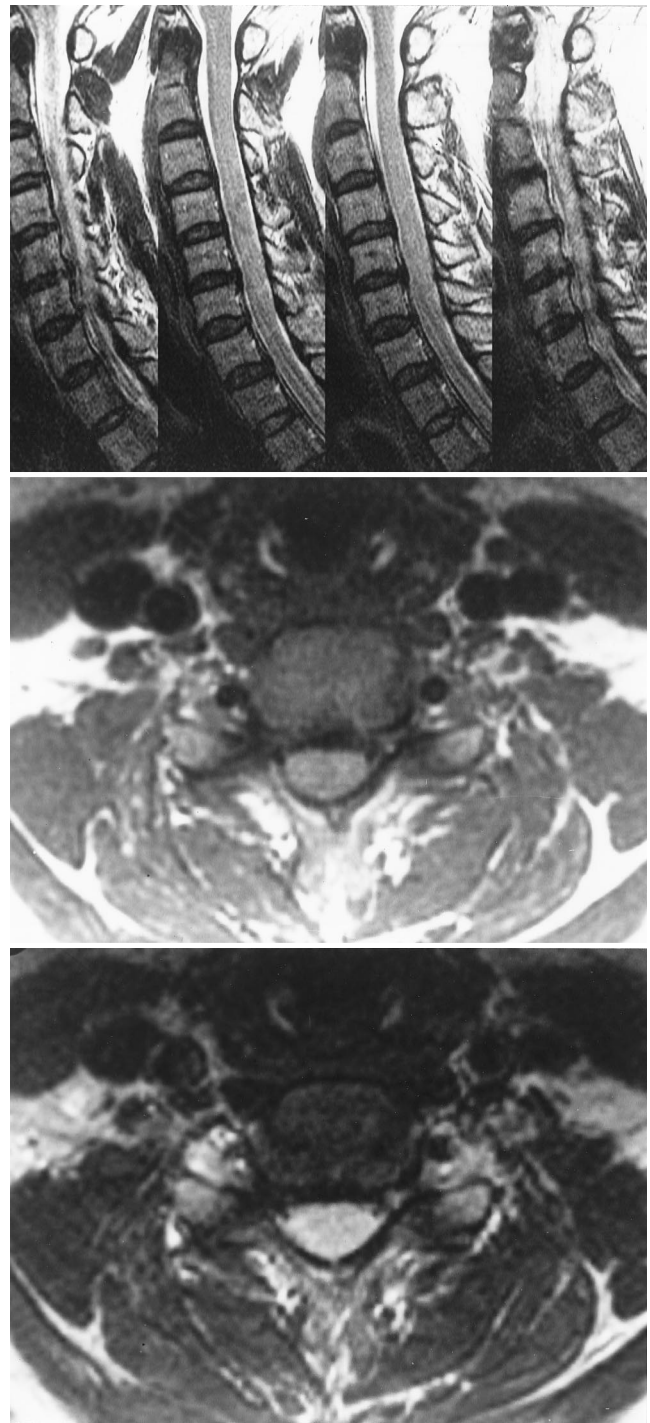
Follow-up MR images 28 months after initial radiographic examination. *Upper:* Cervical T₂-weighted image revealing complete resolution of abnormal cord signal and almost completely regressed disc fragment. *Center and Lower:* Axial T₁- and T₂-weighted images demonstrating the regression of the large disc extrusion at the level of C5-6.
